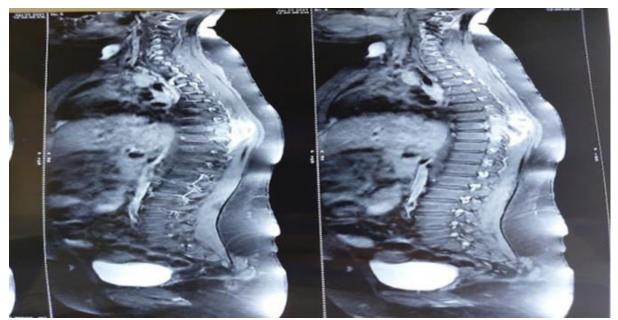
Magnetic resonance imaging (MRI) showing enhancing soft tissue lesion seen in the posterior elements of T8, T9 and T10 vertebral bodies.
